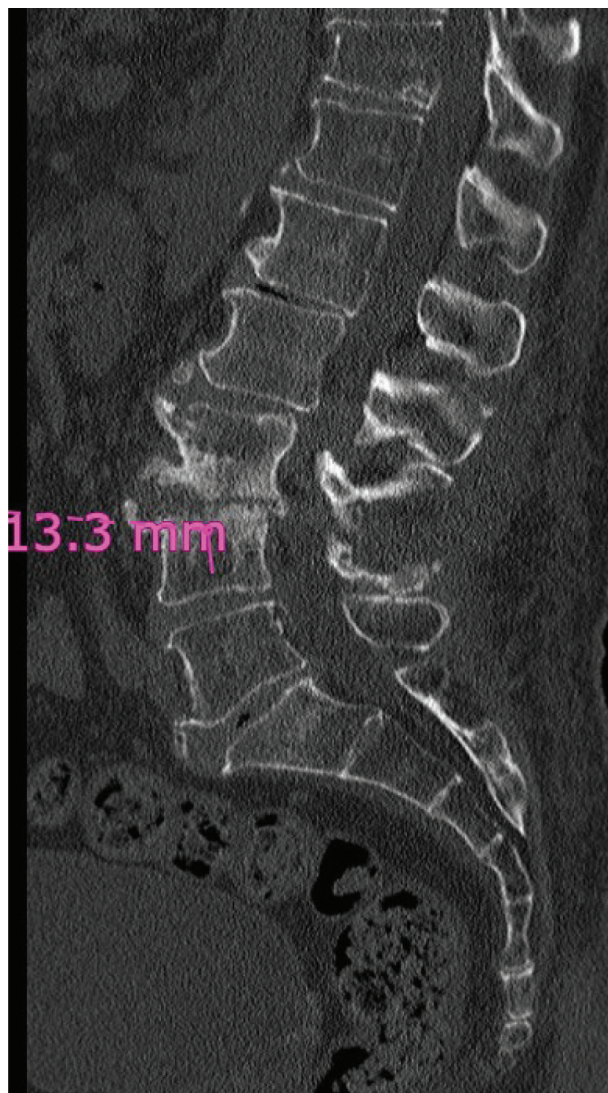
CT showing evidence of L3-L4 osteomyelitis. CT, computed tomography.
